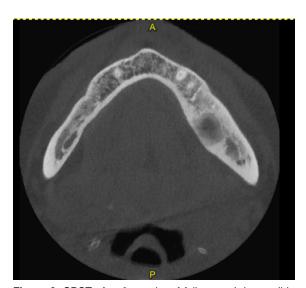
CBCT after 6 months of follow-up. It is possible to see the complete remineralization of cortical bone and progressive healing and mineralization of spongious bone
